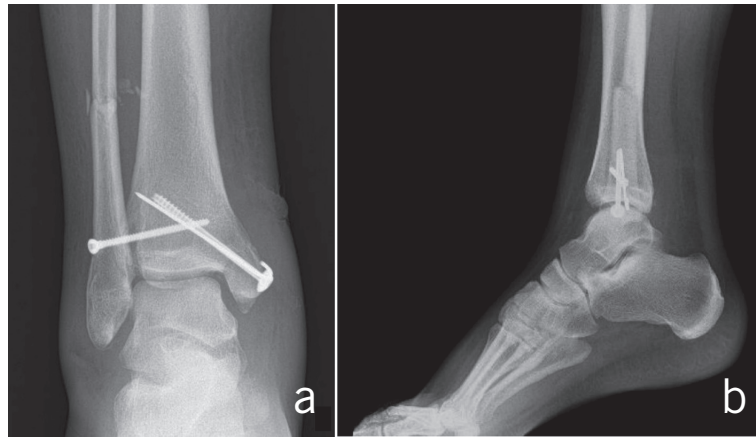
Postoperative anteroposterior (a) and lateral (b) radiographs indicate a successfully obtained reduction.
